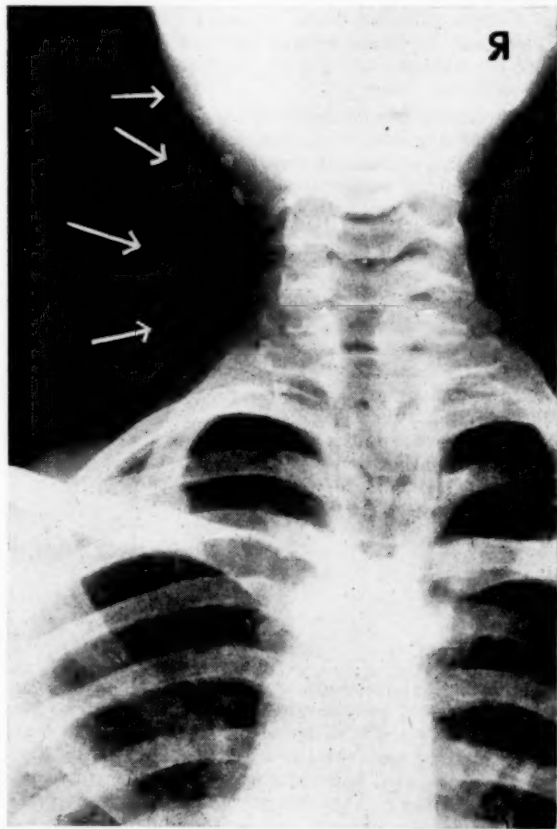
Radiograph of the neck. The arrows demarcate the outer aspect of the soft-tissue mass. Note the phleboliths in the mass and also overlying the left apex of the chest, suggesting extension of the mass downwards into this region.
